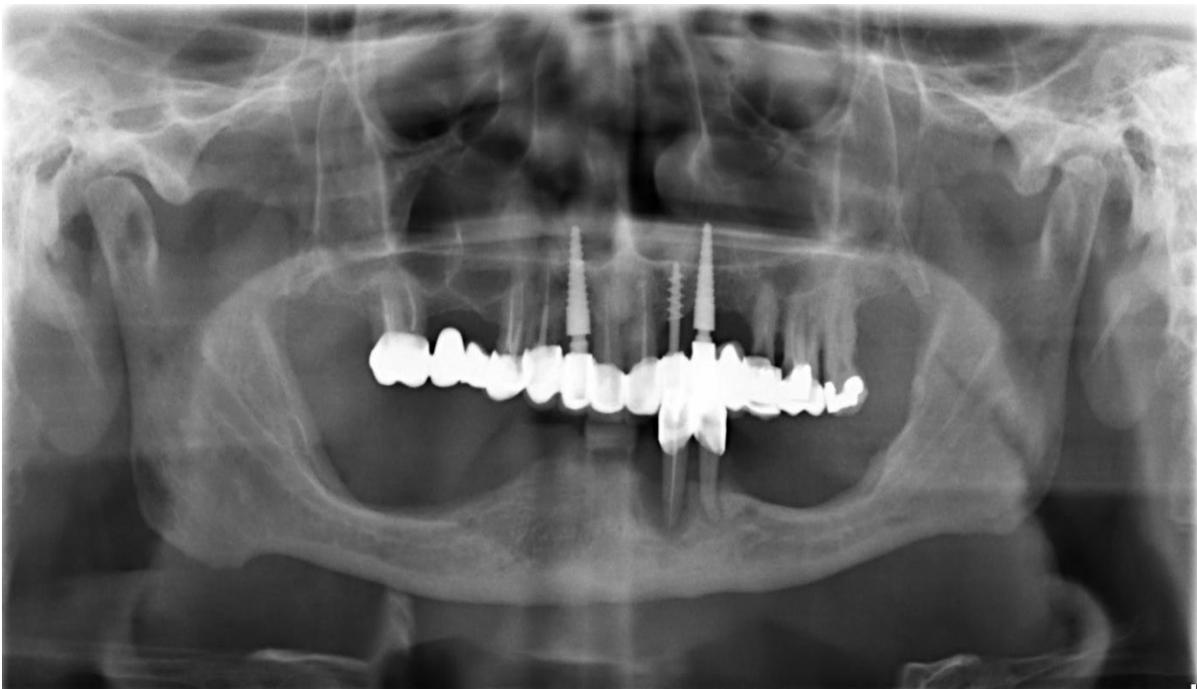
Panoramic radiograph of patient at presentation showing partially edentulous lower arch with resorbed alveolus and remaining lower teeth.
